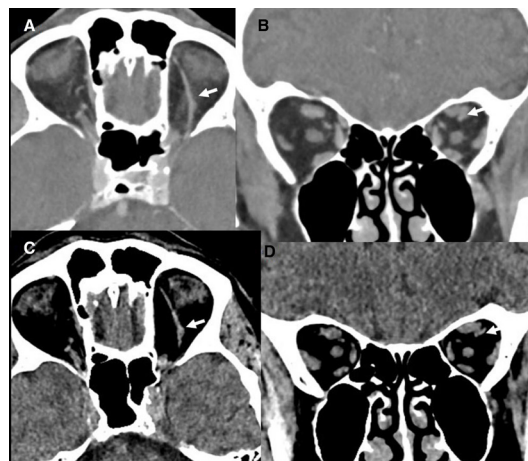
Follow-up scan. Non-contrast CT head (A, B) and CT angiogram (C, D), show a normal superior ophthalmic vein (arrows) on left side in (A, B) and (C, D).
